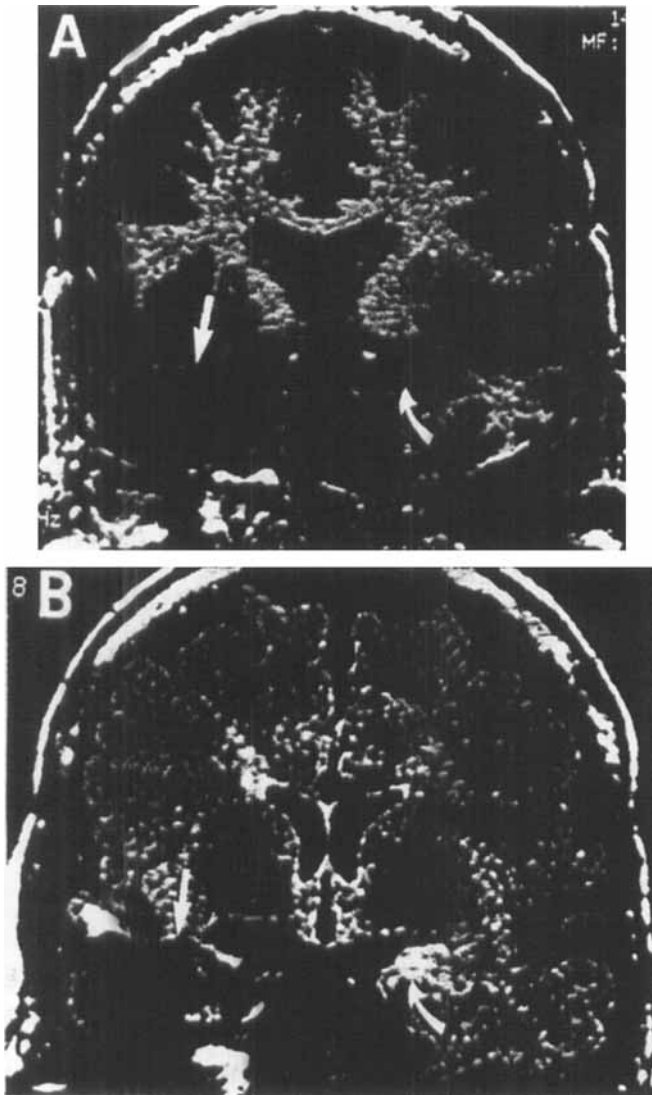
Coronal T1-weighted (A) and fluid-attenuated inversion recovery (FLAIR) T2-weighted (B) images at the level of the amygdala. There is abnormal signal intensity in the left amygdala secondary to gliosis (curved arrows). There is some indication of the left amygdala abnormality in the standard T1 image (A), but it is clearly apparent in the more sensitive FLAIR imaging sequence (B). The absence of the right amygdala secondary to surgery (straight arrows) is also portrayed. The right hemisphere is depicted on the left side of each image.
